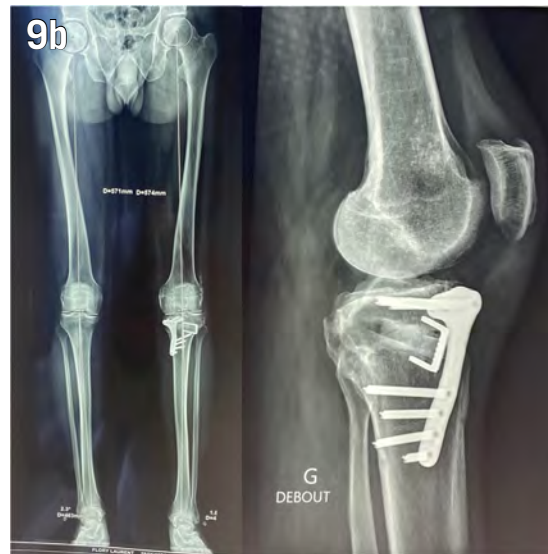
(a and b) Pre-operative and postoperative x-rays of the Case 2.
